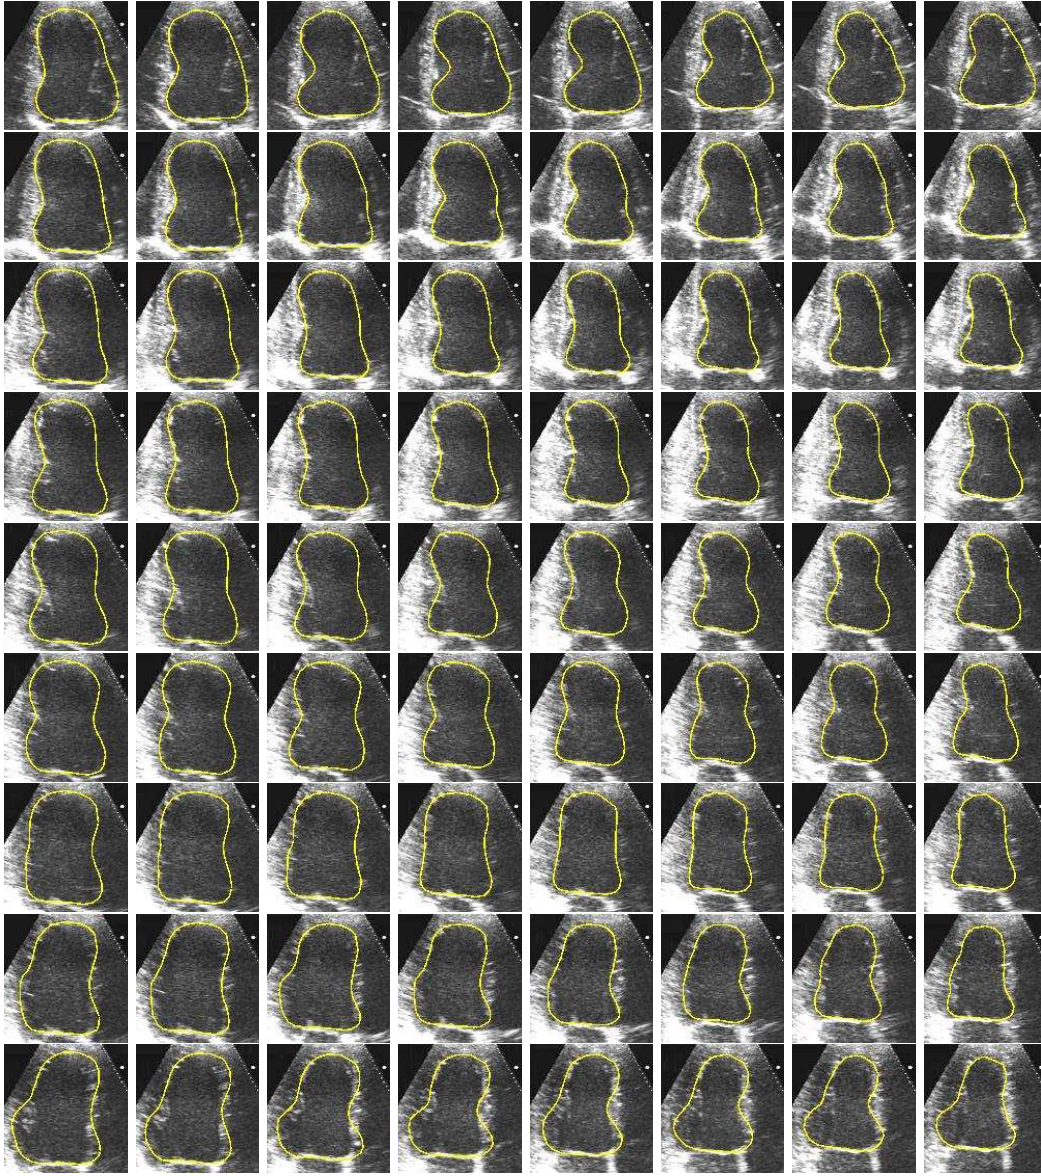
Set of ultrasound slices where deformed model intersections are superimposed. From left to right: cardiac sequence instant. From top to bottom: slices oriented with angle 0, 20, 40, 60, 80, 100, 120, 140, and 160 degrees of arc.
